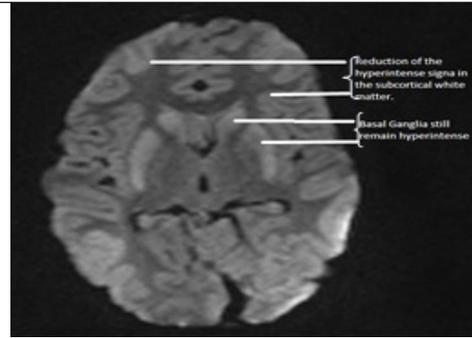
MRI of brain – 1 week after treatment
